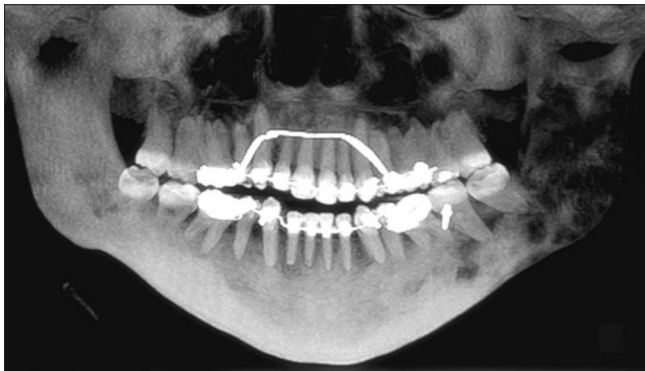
Computed tomography panoramic reconstruction evidencing a multilocular hypodense area compromising the left mandibular ramus and extending to condyle and coronoid process
